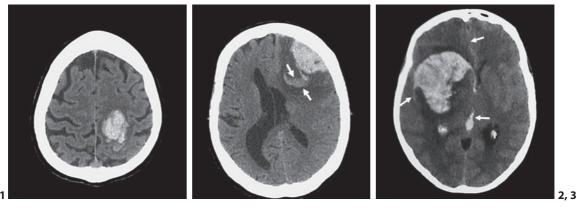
CT without contrast medium shows a left rolandic circumscribed hemorrhage. The patient has a sudden palsy of the right inferior limb, without sensory alteration.
